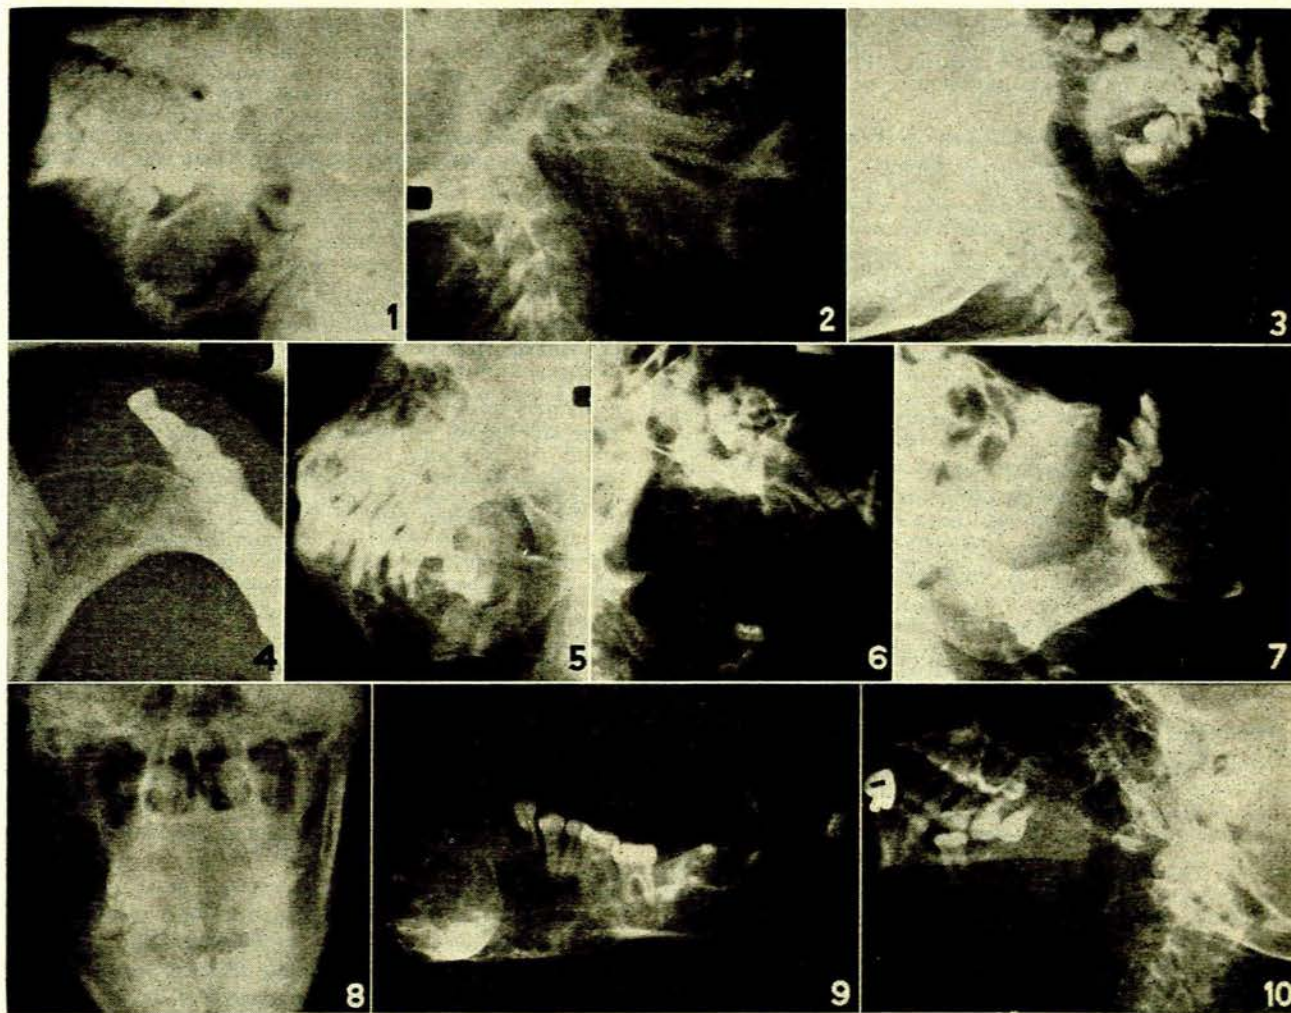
Case 1. Showing a circular radiolucent area in the left ramus. There is a sharply defined margin to this area and the bone pattern beyond is normal. The posterior anterior view (not reproduced) shows expansion of the inner and outer plates of the ascending ramus. The diagnosis made when the X-rays were taken was of a simple cyst. Note the lesser degree of translucency than is usually seen in a simple cyst of the body of the mandible.
